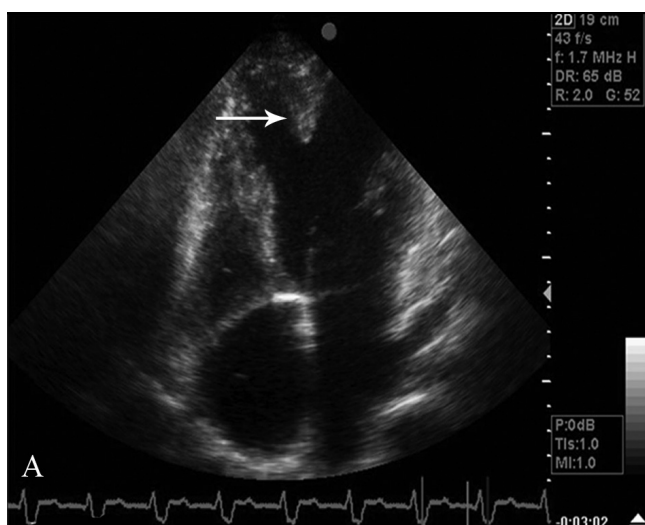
Apical four-chamber (A) and apical short-axis (B) echocardiographic views, revealing an abnormally located papillary muscle in the left ventricular apical portion (arrows)
